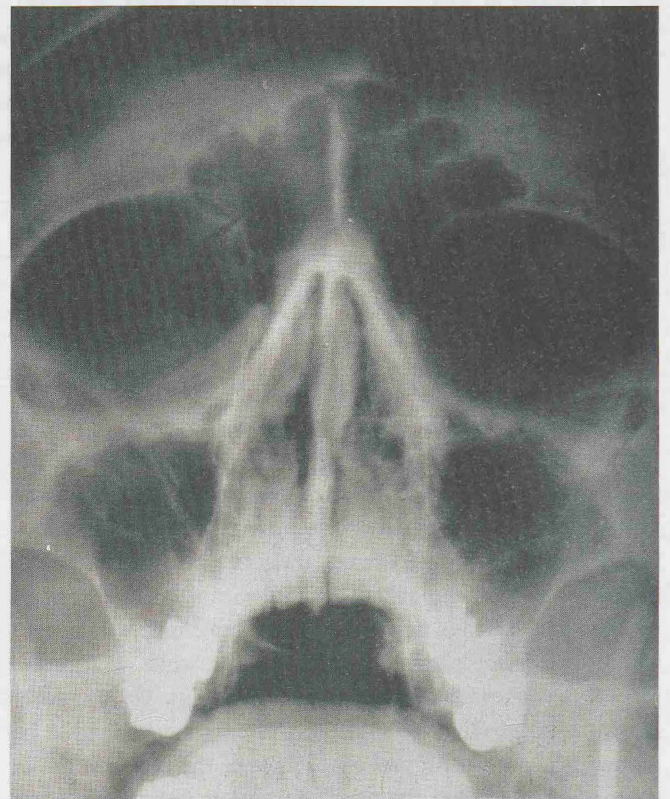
X-ray of the same sinus. The veil-like shade of both maxillary sinuses can be seen. This finding is usually described as "normal sinus transparency."
